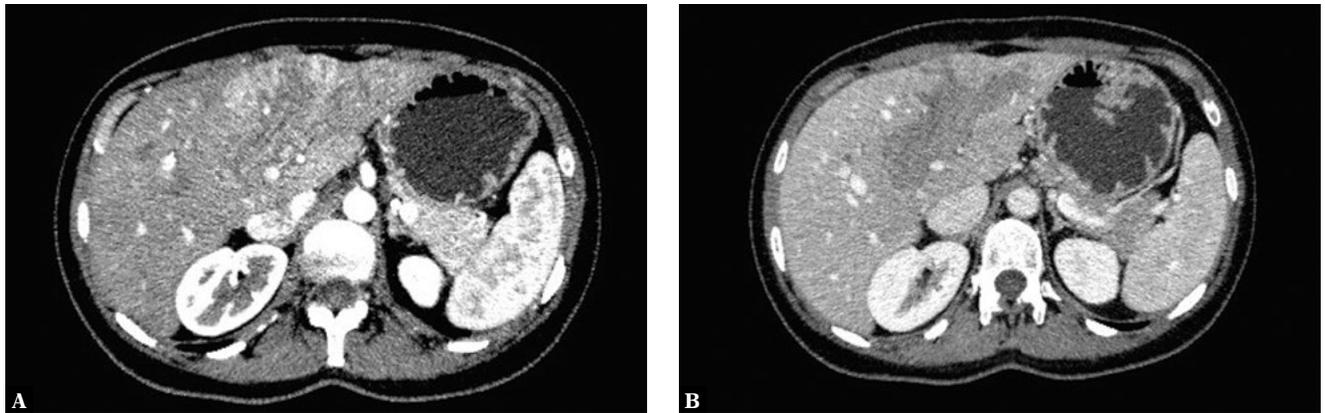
Axial contrast-enhanced CT images show streaky and heterogeneous enhancement of the PV thrombus during the late arterial phase (A) with washout during the portal venous phase (B), which is diagnostic of tumor thrombus
